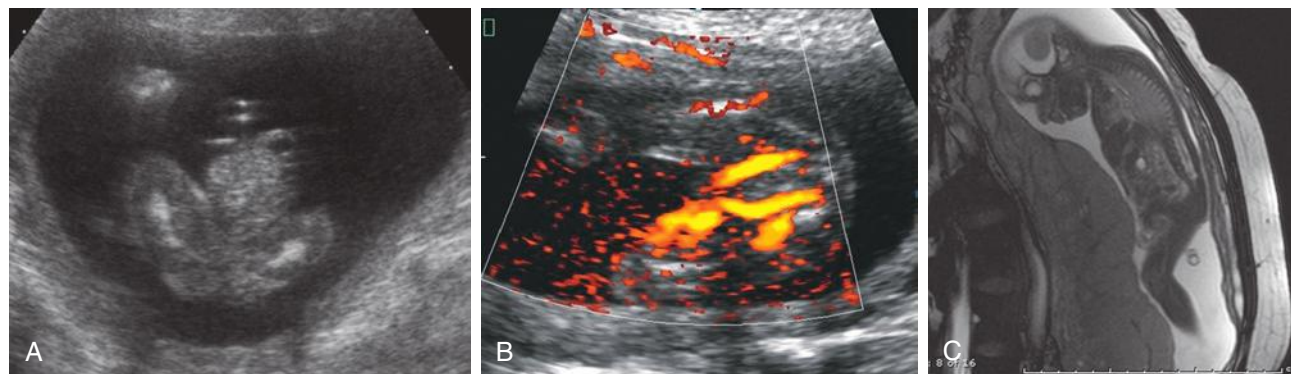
Cloacal extrophy. A, Axial view of lower abdomen showing mass in the lower anterior abdomen. B, Nonvisualization of fetal bladder in the pelvis confirmed by color Doppler identification of umbilical arteries. C, Fetal magnetic resonance imaging aids the diagnosis of cloacal extrophy with demonstration of exteriorized bladder.
